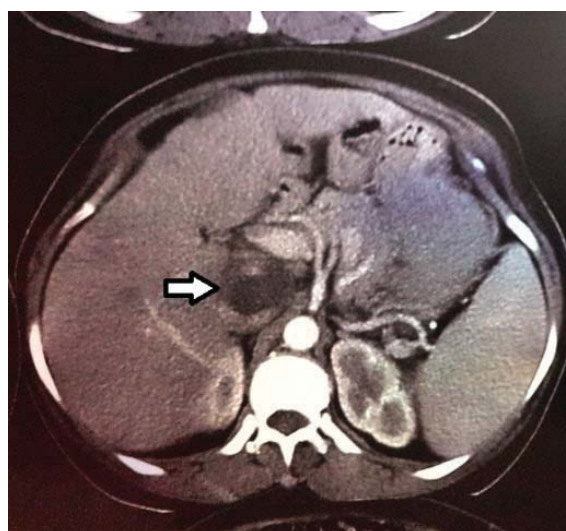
Abdominal Computed Tomography with contrast. The arrow shows the tumoral mass within inferior vena cava.
